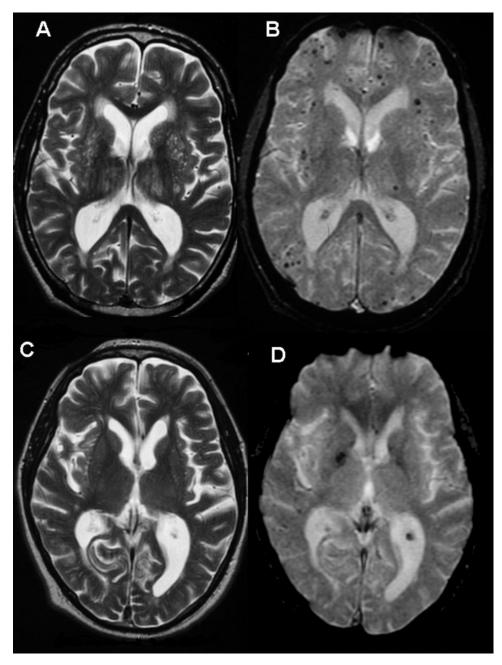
In images A–D the right of the brain is on the left side of the panel. (A) Axial T2-weighted FSE and (B) T2*-weighted gradient-echo MRI of a 63-year-old male patient with executive dysfunction. The T2*-weighted gradient echo (B) shows numerous microbleeds (low-signal intensity foci), particularly in the frontal regions but also in the parieto-occipital regions; these are not visible on the standard T2-weighted FSE. (C) Axial T2-weighted FSE and (D) T2*-weighted gradient-echo MRI of an 81-year-old male patient with executive dysfunction. Two microbleeds are visible in the basal ganglia on the right on the T2*-weighted gradient echo (D), but not the T2-weighted FSE (C).
